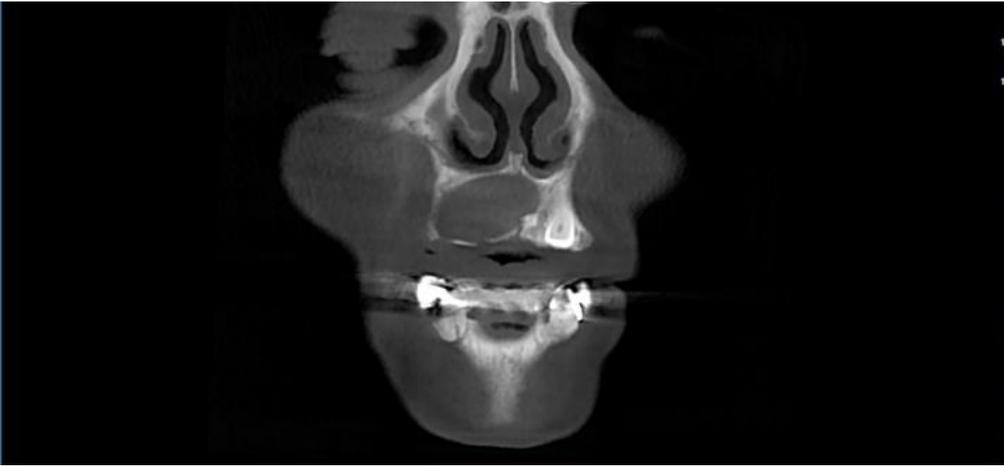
Coronal CBCT showing well defined unilocular radiolucency.
